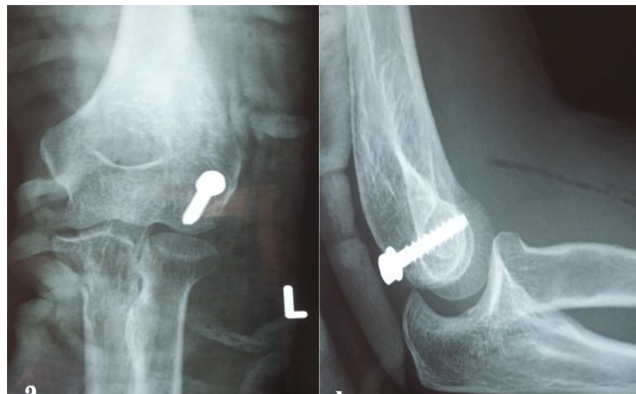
Post-operative radiographs showing accurate anatomical reduction with the implant insitu.
